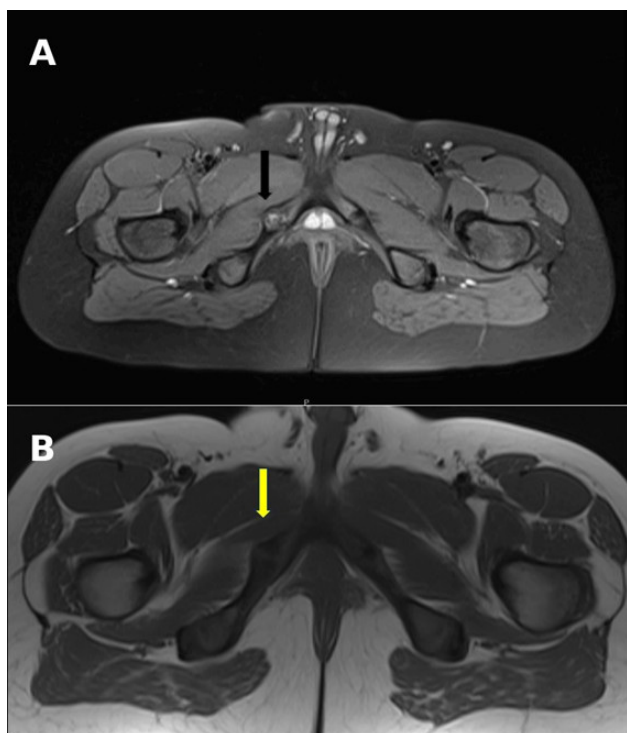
Axial pelvic magnetic resonance images at the level of the ischiopubic rami; (A) Proton density-weighted sequence with fat suppression demonstrating hypertrophy of the right ischiopubic synchondrosis (black arrow), with intraslesional hyperintensity suggestive of edema; (B) T1-weighted sequence showing the same hypertrophy of the right ischiopubic synchondrosis with hypointense signal (yellow arrow).
